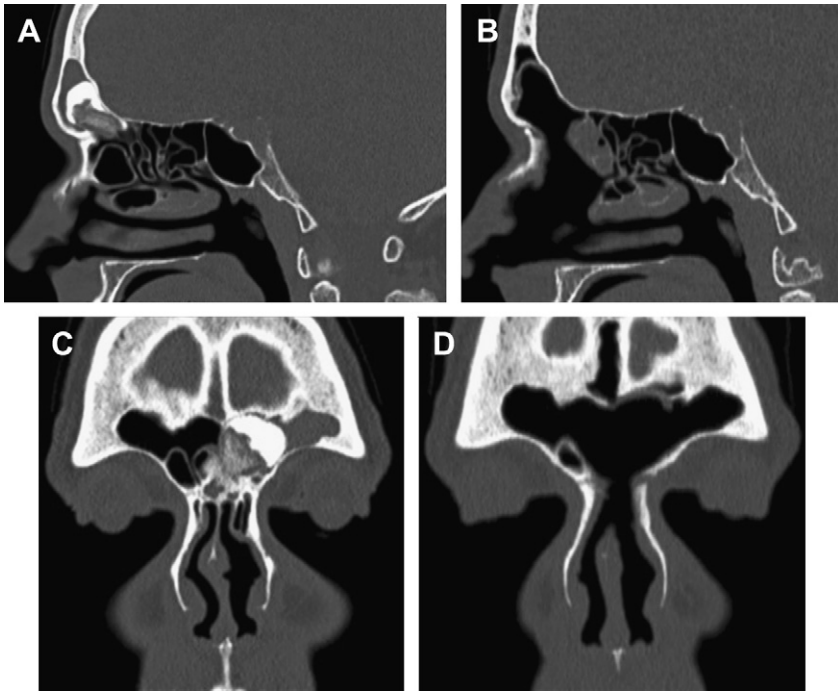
(A–D) Preoperative and postoperative CT scans of a large osteoma attached to the posterior frontal sinus wall, extending more than 2 cm superiorly and completely obstructing the frontal sinus removed endoscopically.
